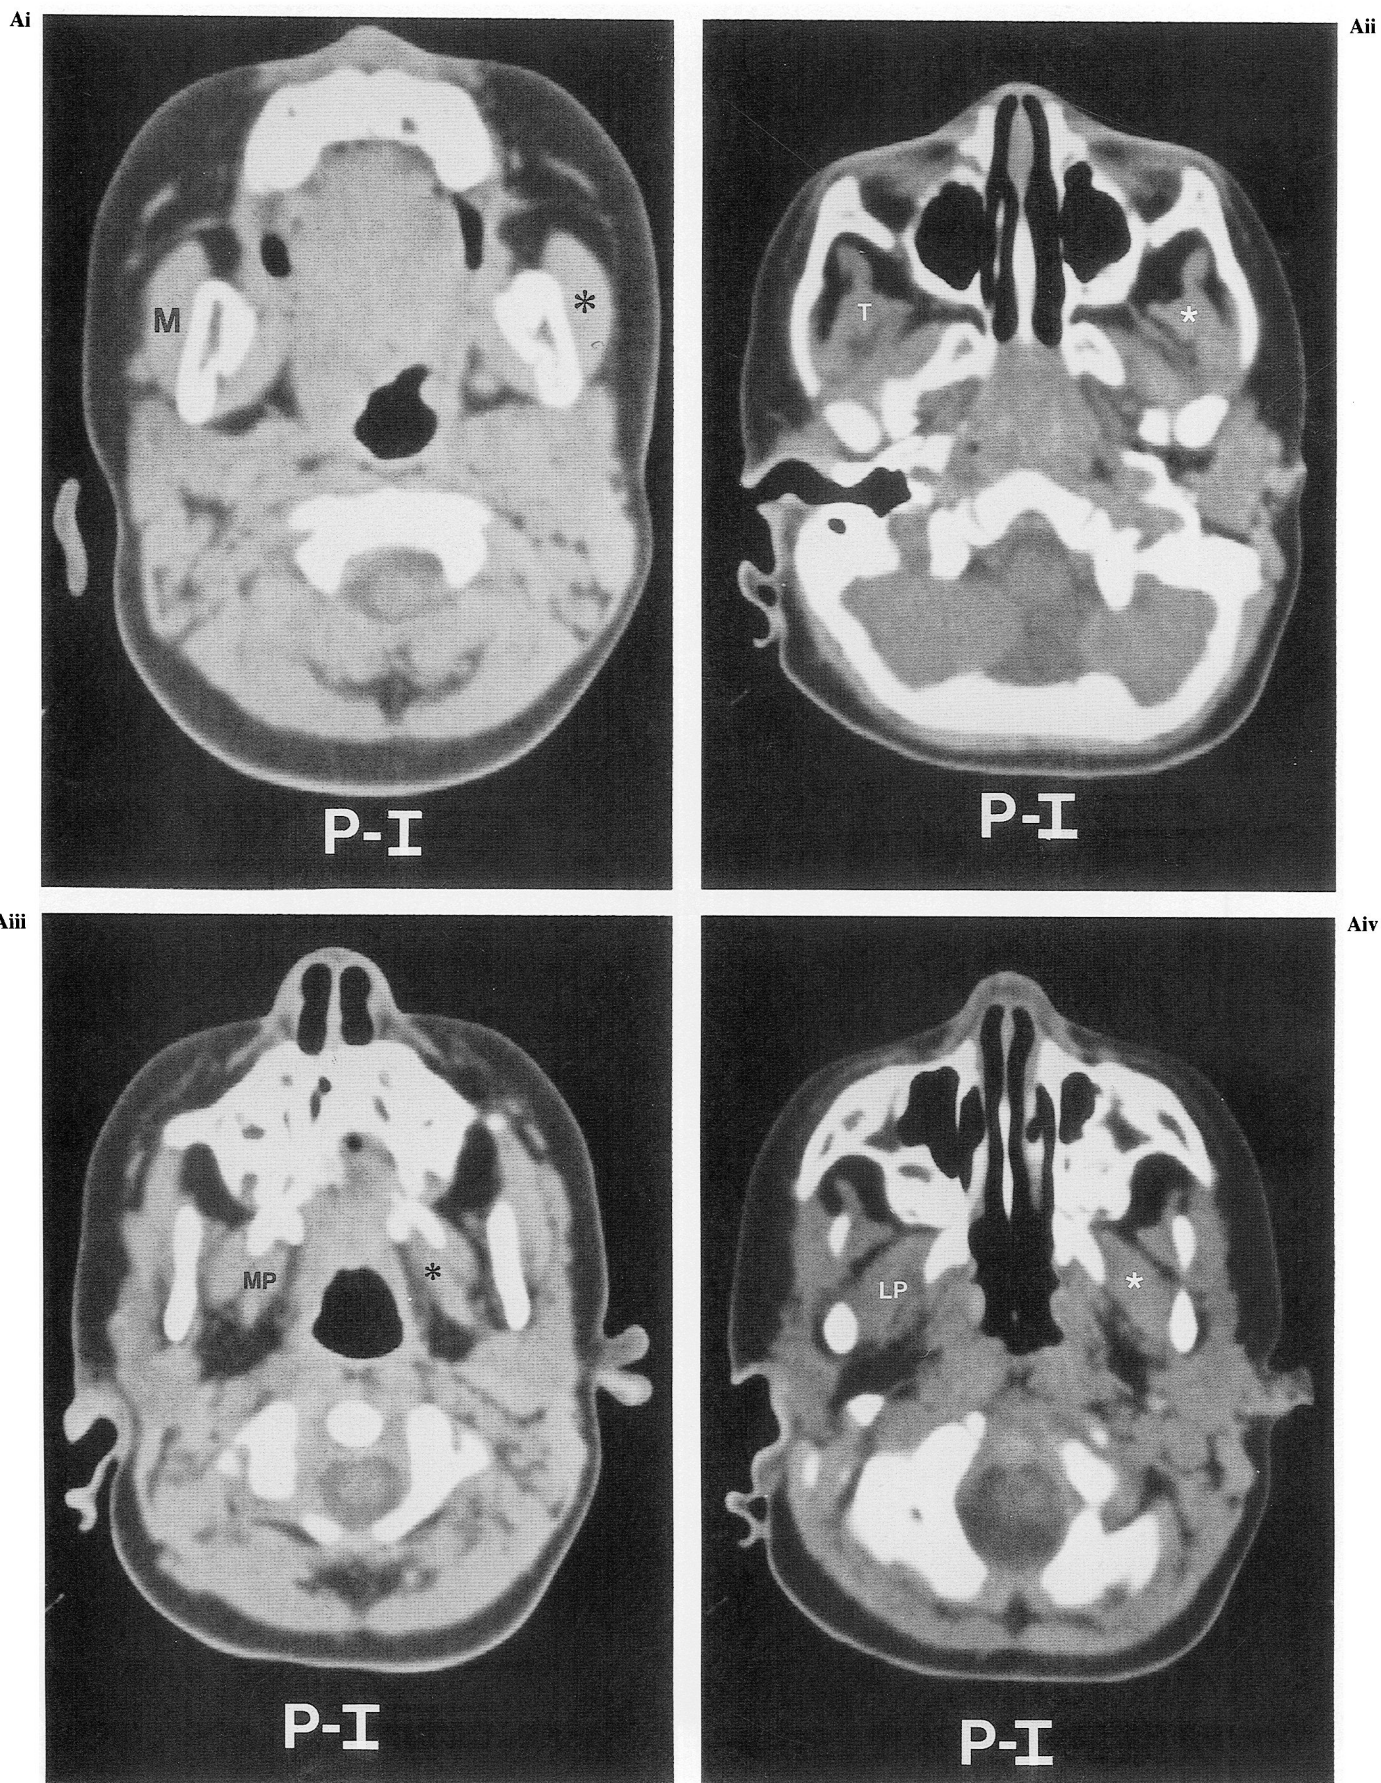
Examples of muscles of mastication on axial CT images. The muscle on the clinically affected side is indicated by an asterisk. The muscle on the clinically unaffected side is indicated by the initial(s) of the muscle: M = masseter; T = temporalis; MP = medial pterygoid; LP = lateral pterygoid. A, 17-month-old male with right unilateral hemifacial microsomia having Pruzansky grade I mandibular dysmorphology (see Fig. 2A). (i), Masseter muscle; (ii), temporalis muscle; (iii), medial pterygoid muscle; (iv), lateral pterygoid muscle.
